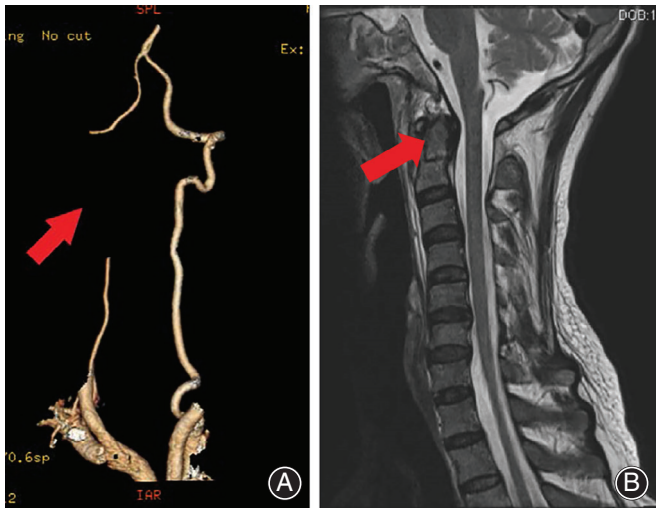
(A) 3D-CTA showed right vertebral artery occlusion (arrows), and the isolated left vertebral artery was dominant. (B) MRI indicated no obvious compression or hydroptic degeneration of the cervical spinal cord (arrows).
